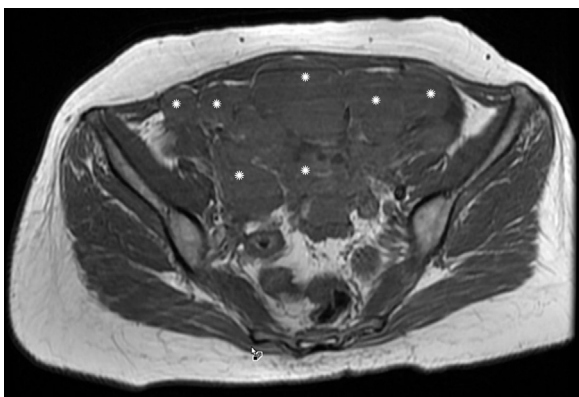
T2-weighted MRI of the pelvis. Pelvic complex mass with bilateral adnexal involvement and omental invasion (asterisk).
